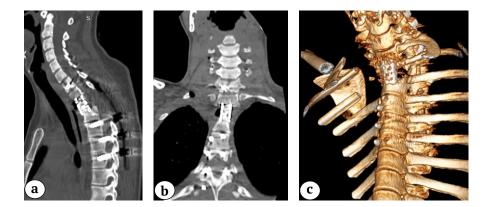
CT images at the time of hospital discharge: a — sagittal view: anterior fusion by titanium mesh-cage with autologous bone graft and posterior screw fixation, correct implant position with angular kyphosis correction; b — frontal view: upper right lung lobe aerated, post-cystic resection cavity; c — 3D scan: right side $1-2^{nd}$ rib costotransverseectomy, anterior Th1-3 fusion by titanium mesh-cage
